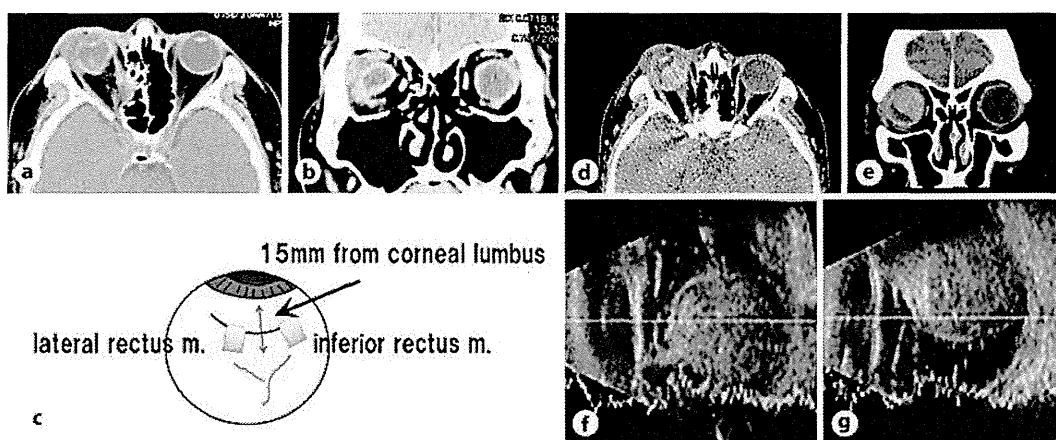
Computed tomography (CT), B mode ultrasonography (B-mode echo), and a scheme showing intraoperative findings of the primary surgery for an open-globe injury. a, b Coronal (a) and transverse (b) images showing distorted right eye globe and orbital fracture. c A Y-shaped wound can be seen between the lateral and inferior rectus muscles and approximately 15 mm behind the limbus. The lateral rectus muscle was temporarily removed and sutured back to the original insertion site after the wound was closed with several interrupted sutures by 8-0 nylon. d, e Coronal (d) and transverse (e) CT images taken on day 4 after the primary surgery. f, g Horizontal (f) and vertical (g) sectioned B-mode echo images taken 3 days after the primary surgery. Massive suprachoroidal hemorrhage occupied about 3/4 of the vitreous cavity at the nasal and superior space.
